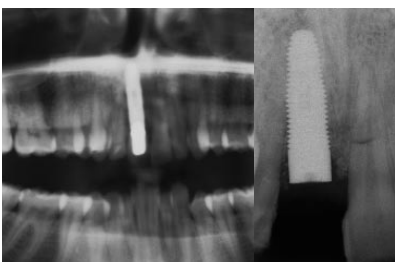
The orthopantomogram 1 year after implant placement.
